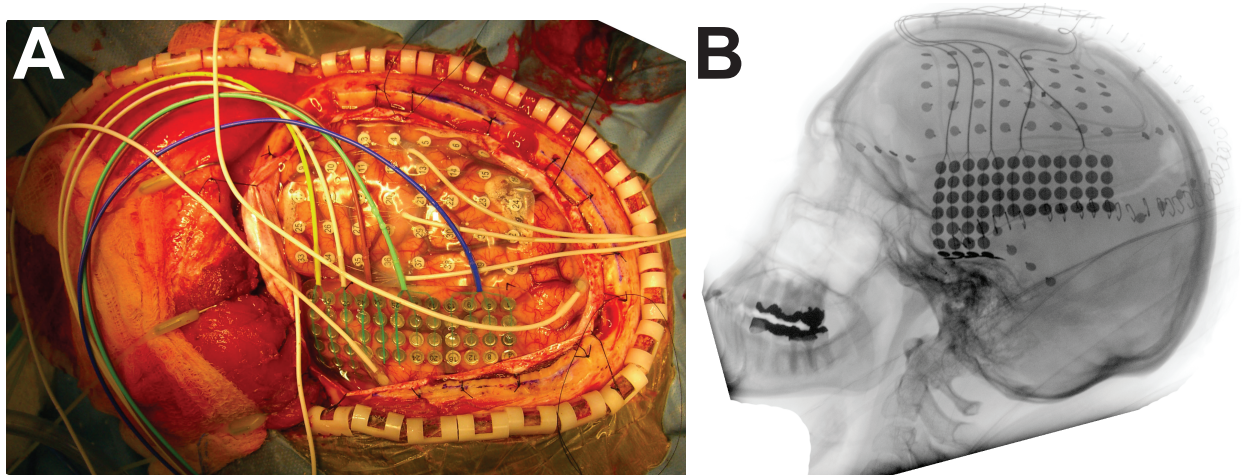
Implantation of ECoG grid. This figure shows two electrode grids implanted on the surface of the brain of a patient with epilepsy. (A) The cortex is exposed through a craniotomy and an incision of the dura. (B) A lateral X-ray of the skull showing the exact location of the electrode grids.
